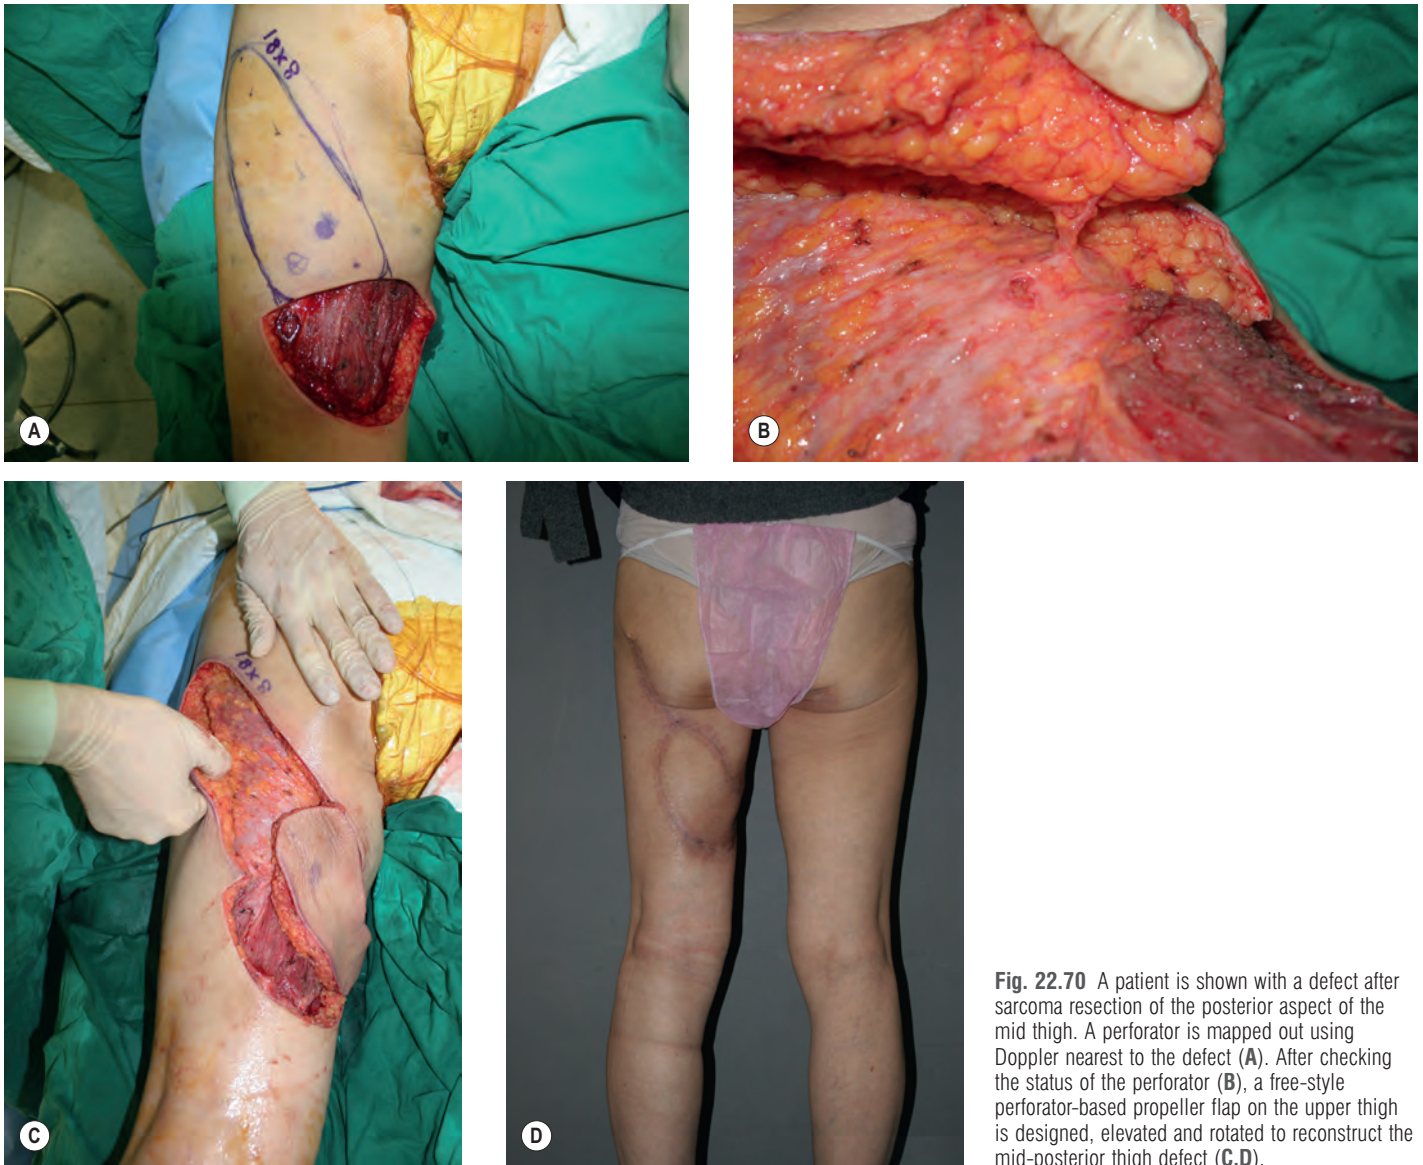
A patient is shown with a defect after sarcoma resection of the posterior aspect of the mid thigh. A perforator is mapped out using Doppler nearest to the defect (A). After checking the status of the perforator (B), a free-style perforator-based propeller flap on the upper thigh is designed, elevated and rotated to reconstruct the mid-posterior thigh defect (C,D).
